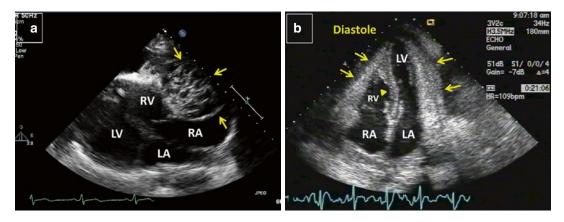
Pericardial tumors. Panel a: Benign lymphangiomas of the pericardium – Transthoracic echocardiogram in an off-axis parasternal view demonstrate a large cystic tumor (*arrows*). The findings are consistent with but not pathognomonic for lymphangiomas (Courtesy from Dr. Adam Skolnick , Division of Cardiology, New York University Langone Medical Center). Panel b: Malignant
